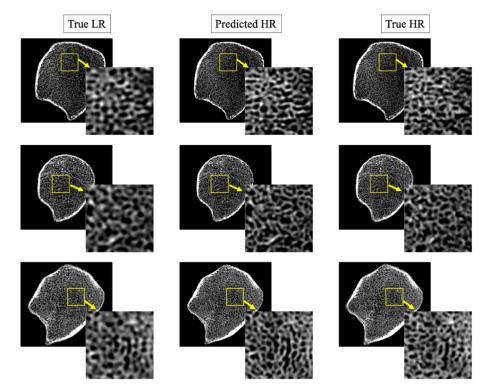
Results of HR prediction from LR trabecular bone CT scans using GAN-CIRCLE. Left-to-right columns: matching 2D image slices from true LR, predicted HR, and true HR CT data. LR and HR CT images of distal tibia were acquired on a Siemens FLASH and FORCE scanners, respectively. Three different rows represent images from three different human subjects.
